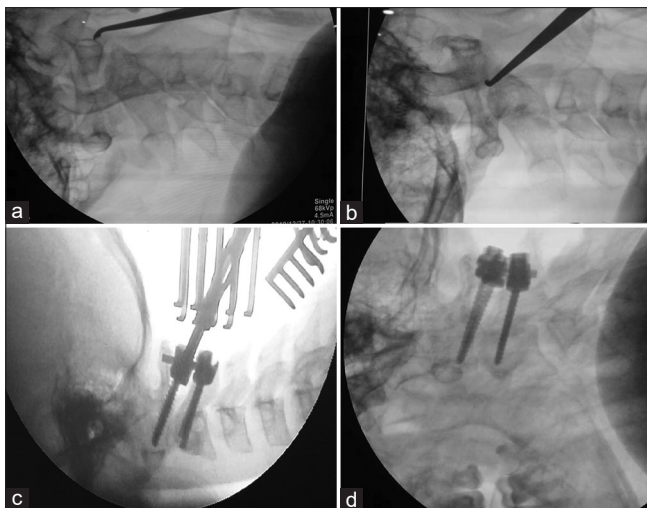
(a) Intraoperative X-ray with patient in supine position. Anterior arch of atlas confirmed with lateral image. (b) Small curette inserted between C2 vertebral body and lower surface of fractured odontoid after release. The surfaces are being prepared for fusion. (c and d) Patient in prone position. C1 Lateral mass and C2 pedicle screws inserted.
